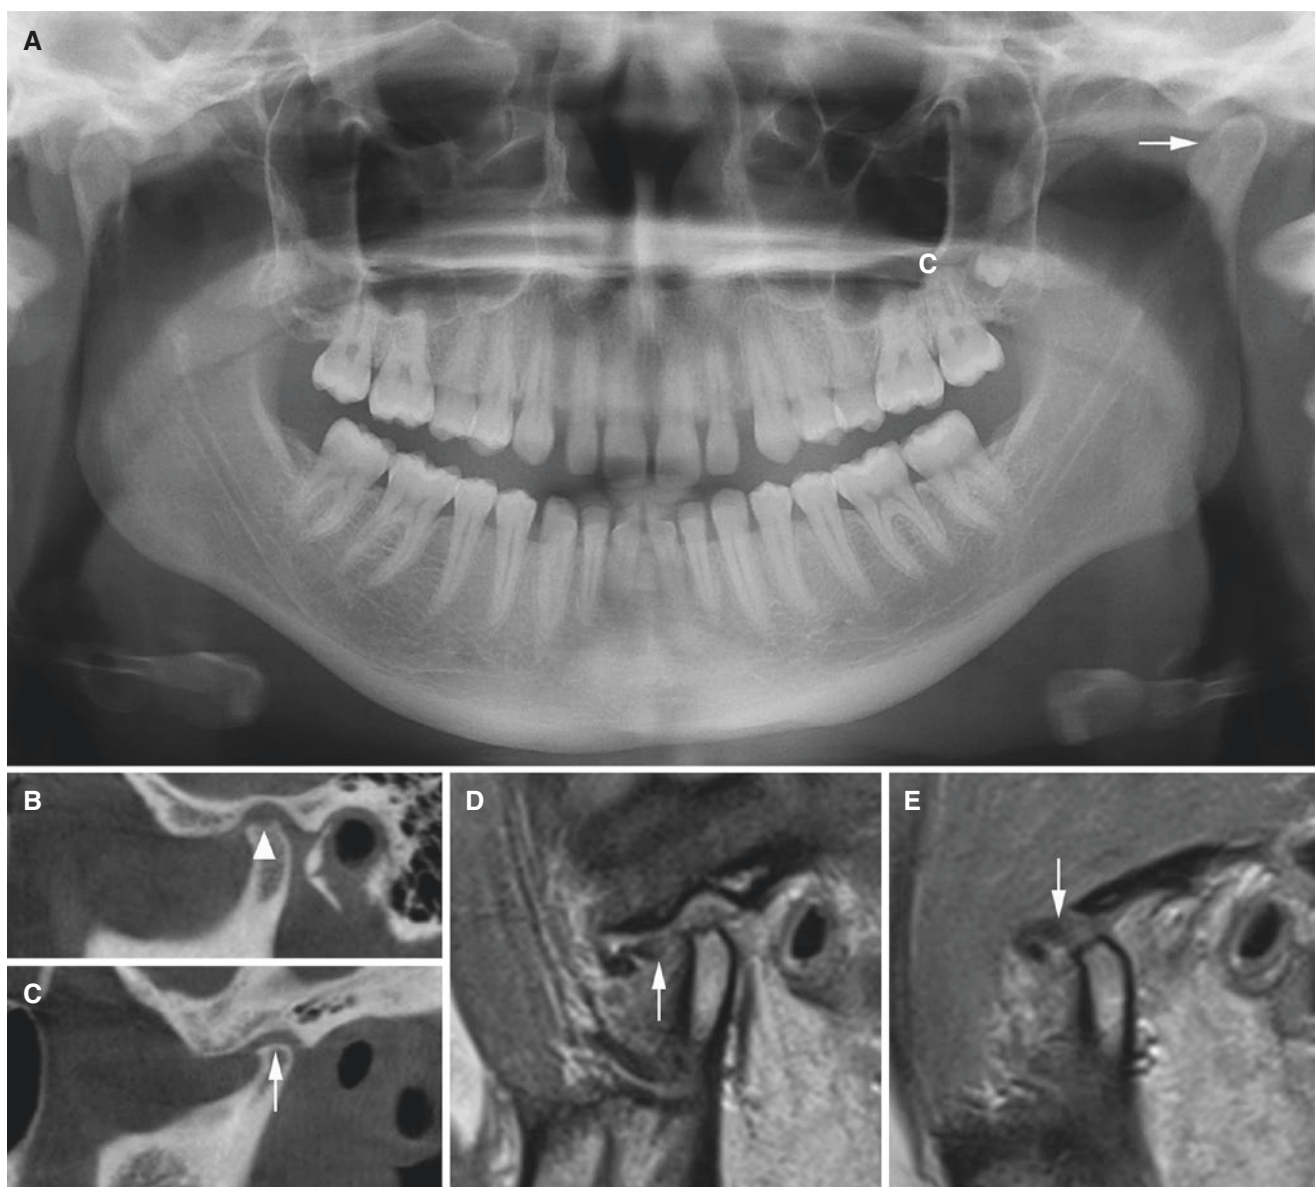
Juvenile osteoarthritis; 18-year-old female. (A) Panoramic view shows jaw asymmetry with flattened left condyle (*arrow*). (B) Oblique sagittal CT image of the right joint shows condylar erosion (*arrowhead*). (C) Oblique sagittal CT image of the left joint shows
